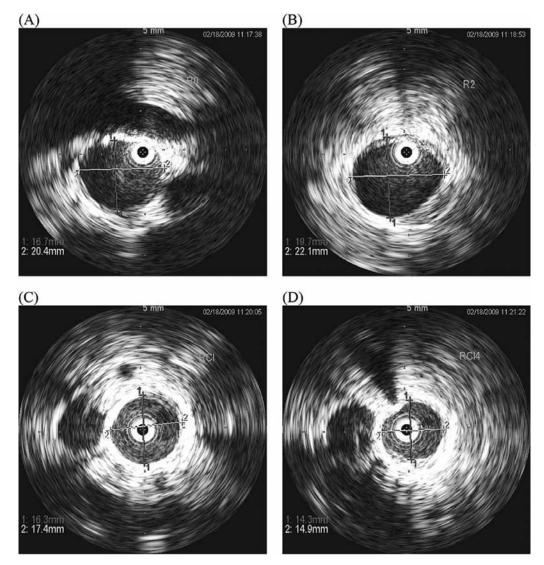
Intravascular ultrasound images obtained from the aorta demonstrating A. the position of the lowest renal artery (R0) and the left renal vein position at the top of the image; B. the distal extent of the proximal landing zone 2 cm below the renal arteries (R2); C. the right common iliac artery (RCI); and D. the diameter of the distal common iliac artery (RCI4). (Reprinted from Pearce BJ, Jordon WD. Using IVUS during EvAR and TEVAR: Improving patient outcomes. Seminars in Vascular Surgery. 22: pp. 172–180. Copyright 2009 with permission from Elsevier.)
